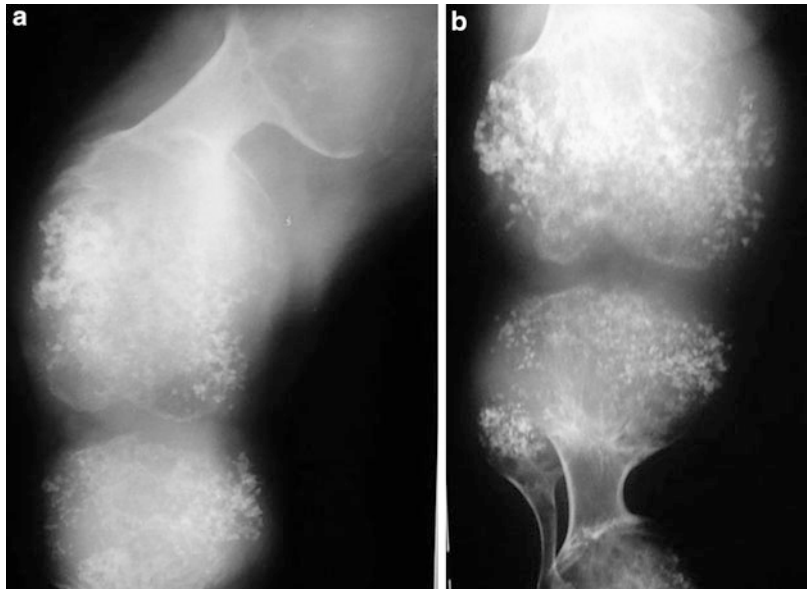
A 4-year-old boy was seen because of swelling of phalangeal joints of multiple fingers on both hands with occasional joint pain. No vascular malformation was detected. Clinical and radiographic findings are consistent with Ollier disease
